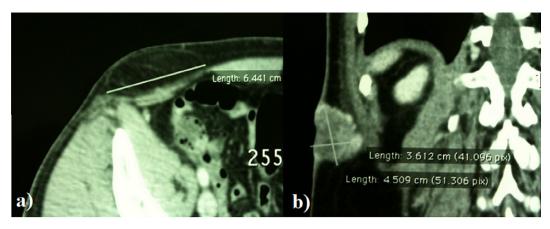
CT scan after use of contrast agents showed hyperdense, ill-defined and not enhanced lesion of the flank that comes in contact with the right oblique muscles. (a) Axial section image. (b) Frontal section image.
